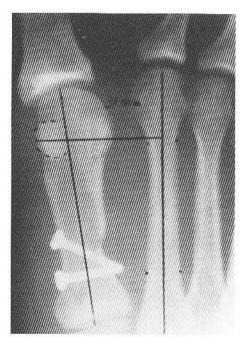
Postoperative x-ray of a closing base wedge osteotomy-McBride bunionectomy showing reduction of the hallux abductus angle, the intermetatarsal angle, and the tibial sesamoid position. The tibial sesamoid - second metatarsal distance remains essentially unchanged.
